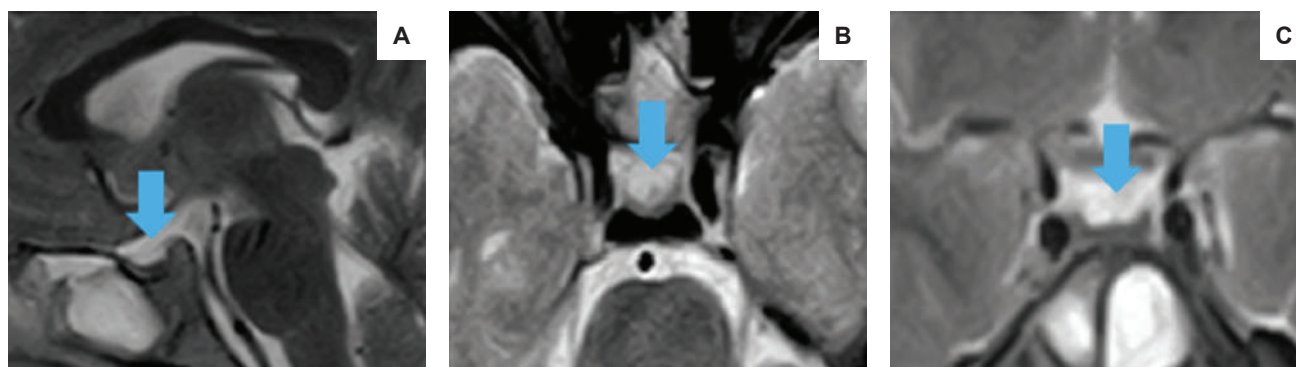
Cranial MRI (A) T2 sagittal view; (B) T2 axial view; (C) T2 coronal view. The arrows point to fluid-filled sella.
